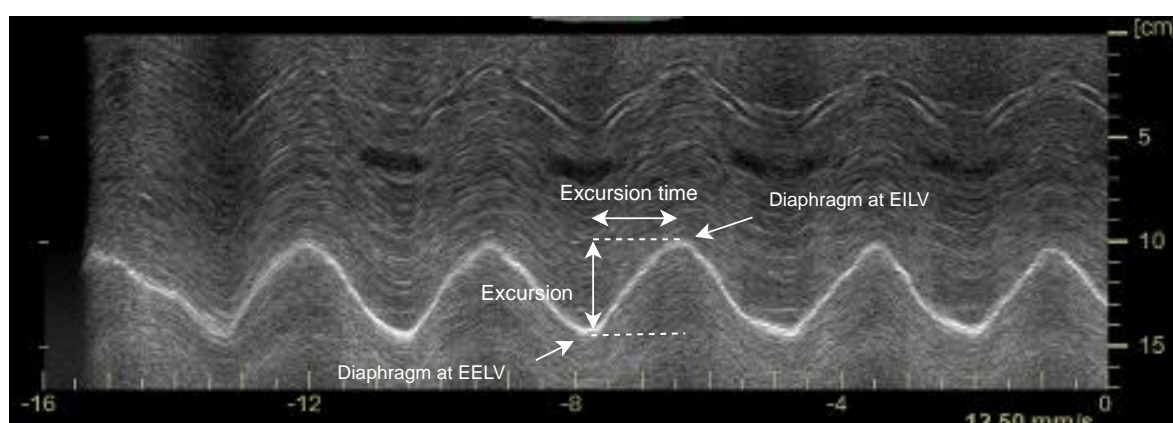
Conventional M-mode and AM-mode ultrasound of crural diaphragm excursion. The ordinate is the distance (cm) from the transducer, and abscissa is shown time (s). Using a digital calliper tool, diaphragm excursion was measured as the absolute excursion amplitude from onset of excursion (e.g., at EELV) to peak excursion (e.g., at EILV), as indicated by arrows. In this example, diaphragm excursion was  $\sim 4.8$  cm and excursion time was  $\sim 2$  s during hyperpnoea in a female participant.
